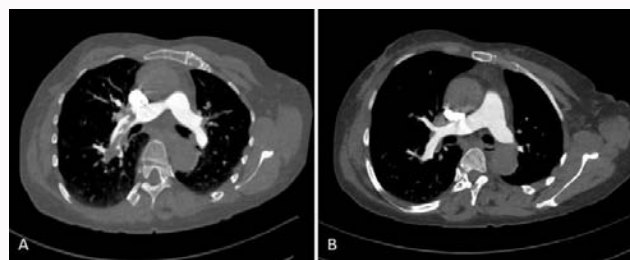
Computed tomography scan showed thrombosis in the right main pulmonary arteries (A: before anticoagulants; B: after anticoagulants).
